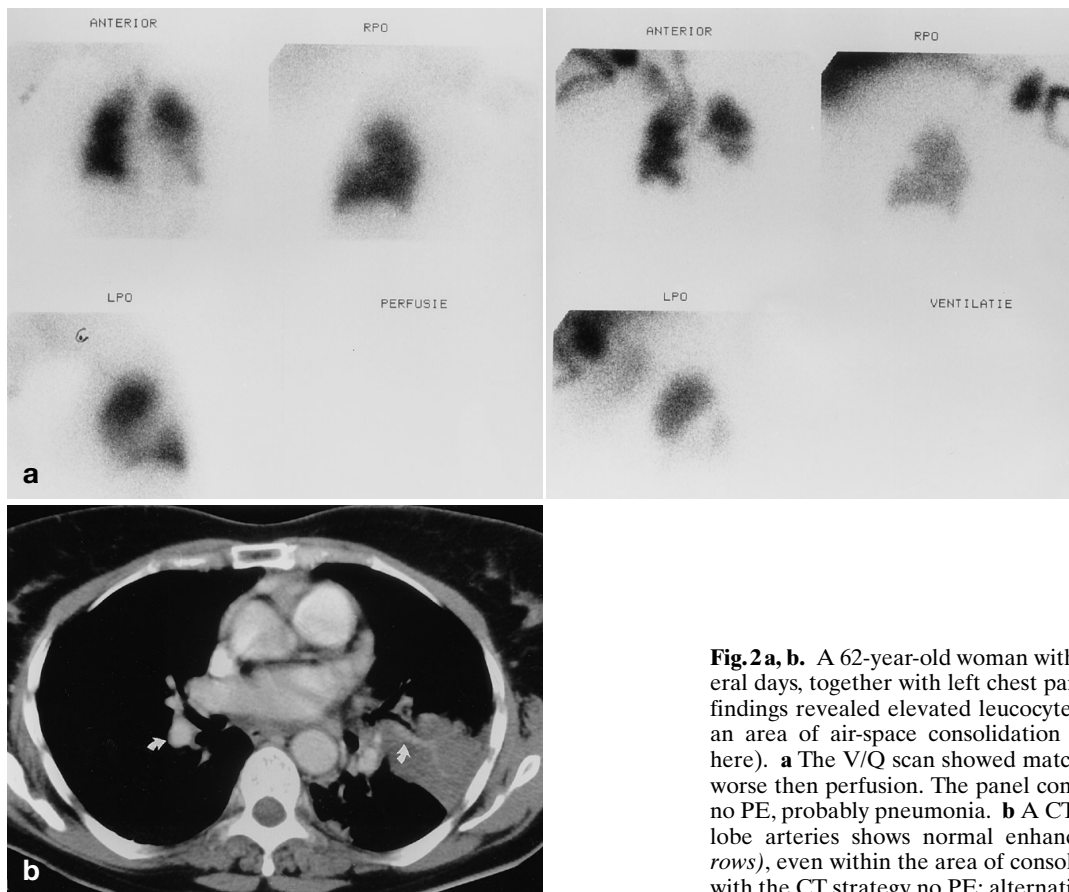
A 62-year-old woman with cough and dyspnoea for several days, together with left chest pain and mild fever. Laboratory findings revealed elevated leucocytes count. Chest X-ray showed an area of air-space consolidation on the left side (not shown here). a The V/Q scan showed matching defects, ventilation even worse than perfusion. The panel concluded with the V/Q strategy no PE, probably pneumonia. b A CT scan at the level of the lower lobe arteries shows normal enhancing pulmonary arteries (arrows), even within the area of consolidation. The panel concluded with the CT strategy no PE; alternative diagnosis: pneumonia
